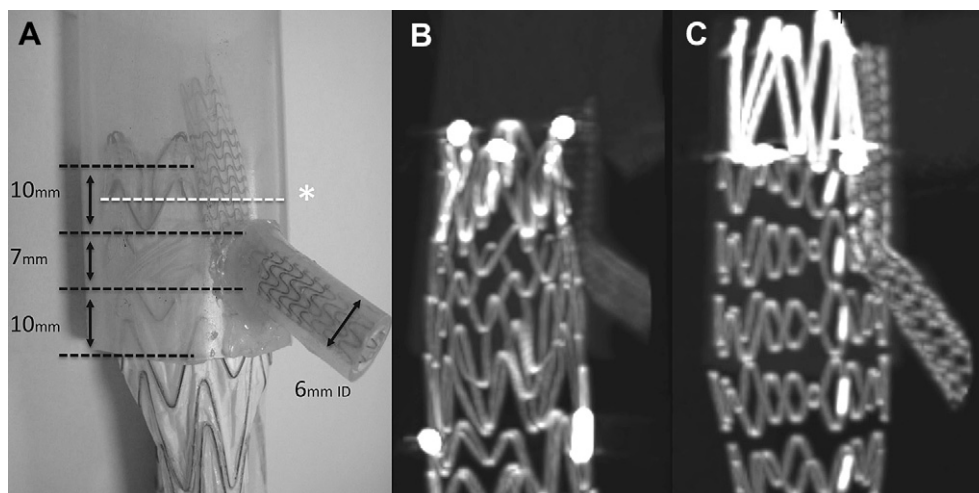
A) Endograft and parallel stent inside the silicon juxtarenal aortic model (Excluder–Viabahn combination), with 3 marked zones, visceral branch diameter (6 mm ID: inner diameter) and the site of axial measurements on CT scan (*). B) 3D reconstruction after CT scan of Excluder–Viabahn combination, and C) Endurant–V12 combination.
